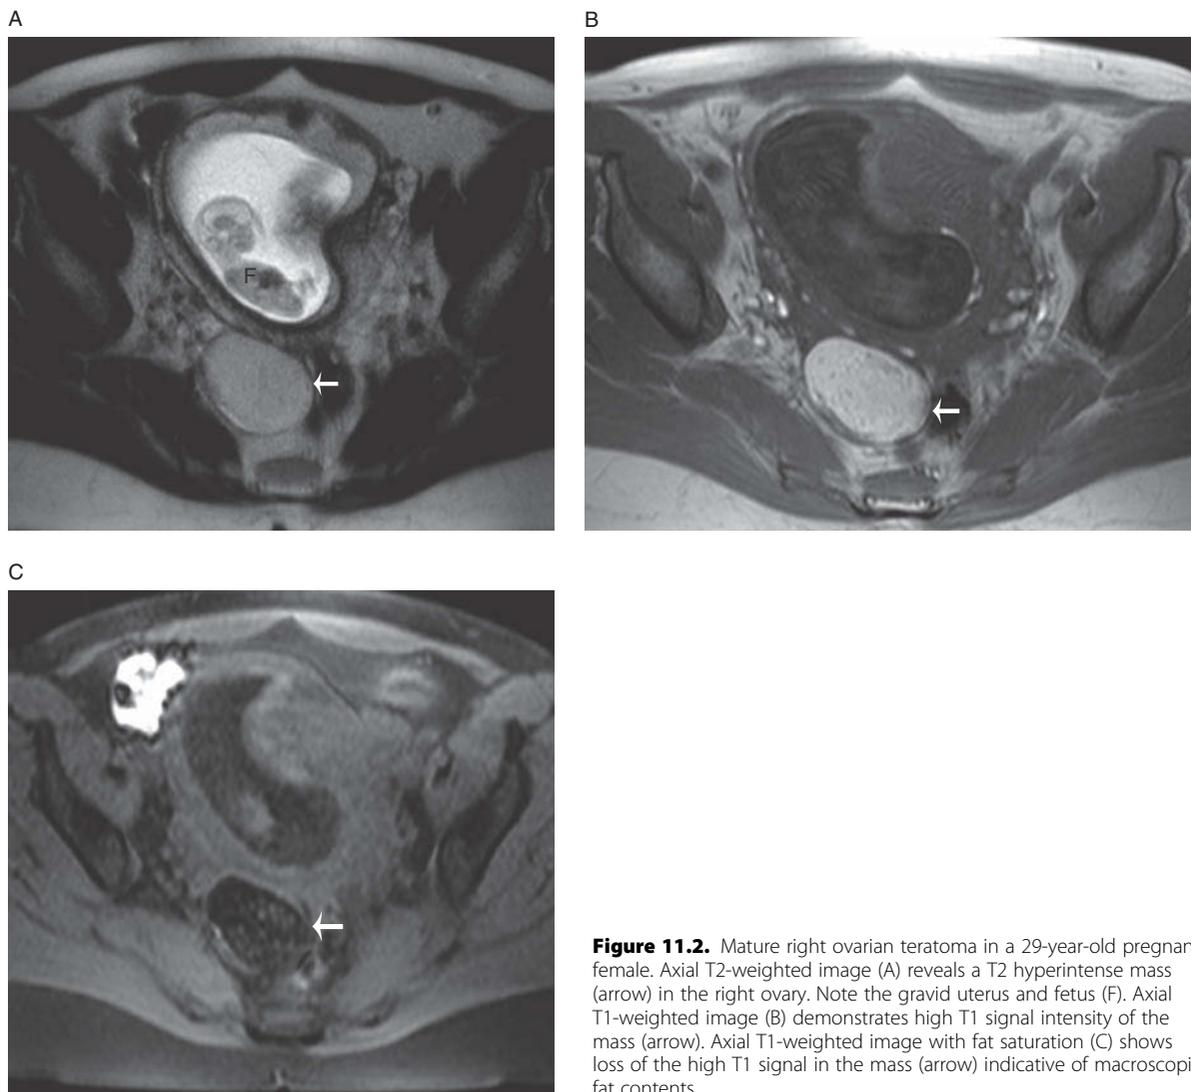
Mature right ovarian teratoma in a 29-year-old pregnant female. Axial T2-weighted image (A) reveals a T2 hyperintense mass (arrow) in the right ovary. Note the gravid uterus and fetus (F). Axial T1-weighted image (B) demonstrates high T1 signal intensity of the mass (arrow). Axial T1-weighted image with fat saturation (C) shows loss of the high T1 signal in the mass (arrow) indicative of macroscopic fat contents.
